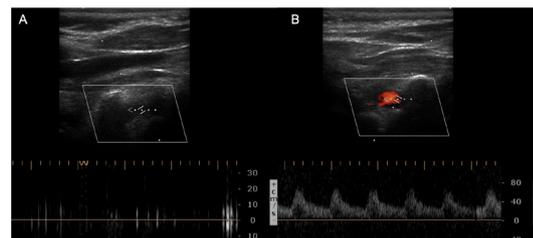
Supra-aortic trunk Doppler shows the right vertebral artery without flow (A), compatible with severe stenosis or occlusion, with normal flow in the contralateral artery (B).
